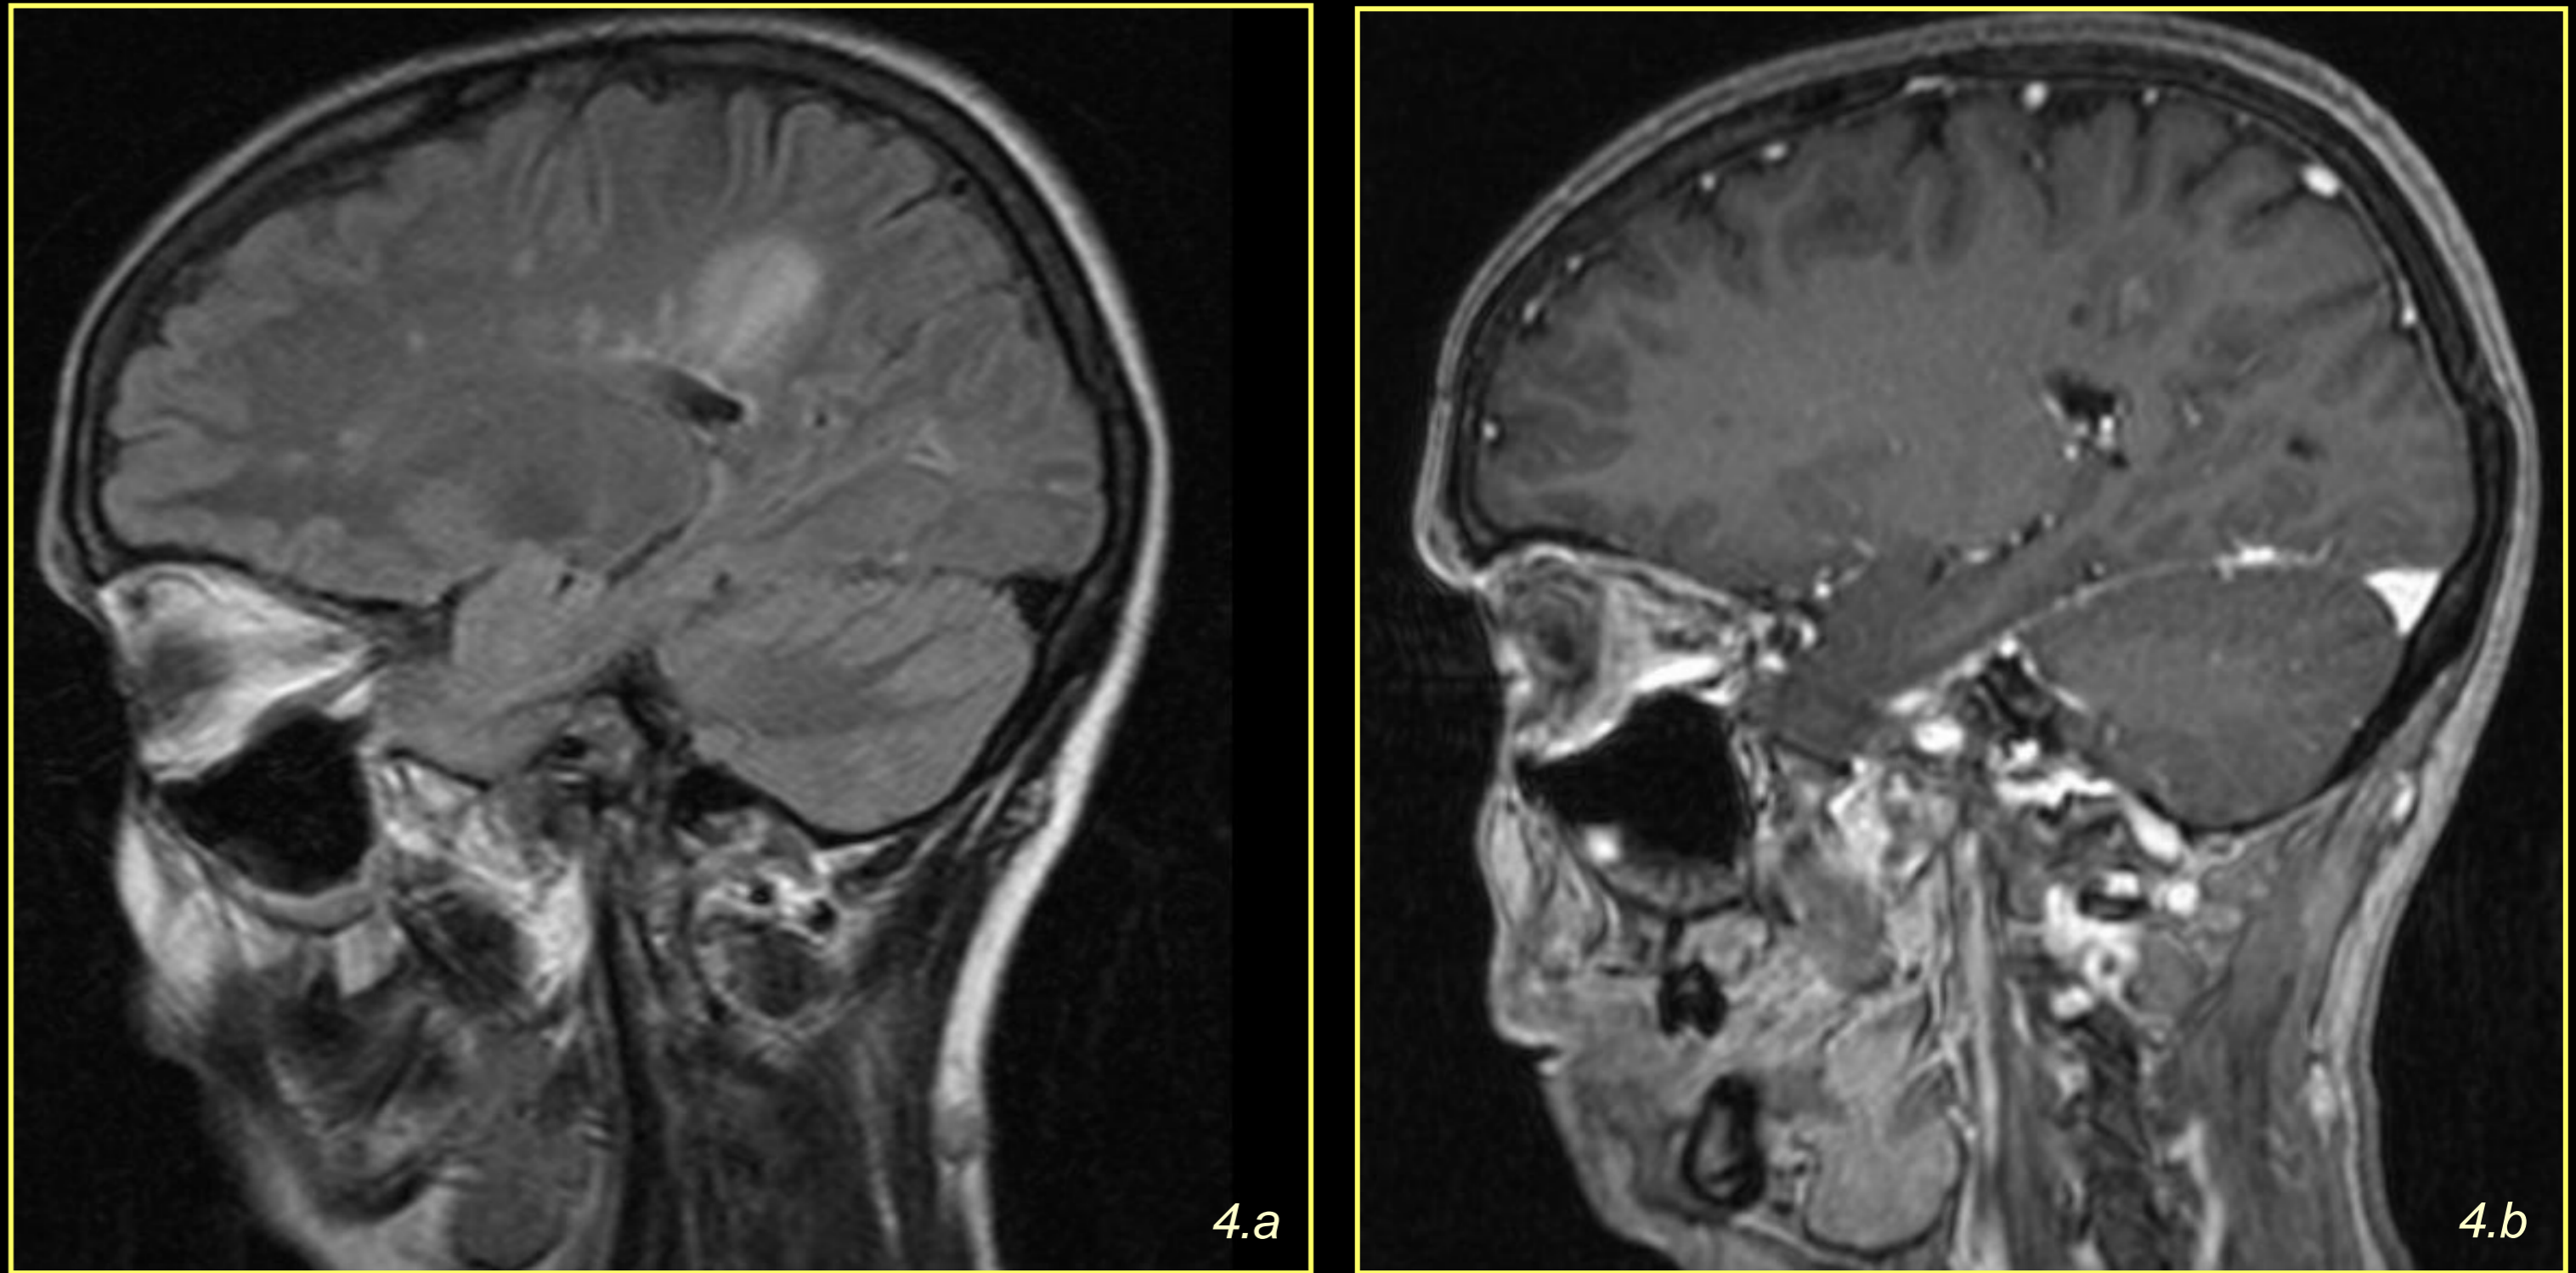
A 41-year-old woman with MS. a) Sagittal FLAIR image. b) Axial post-contrast T1-WI.
